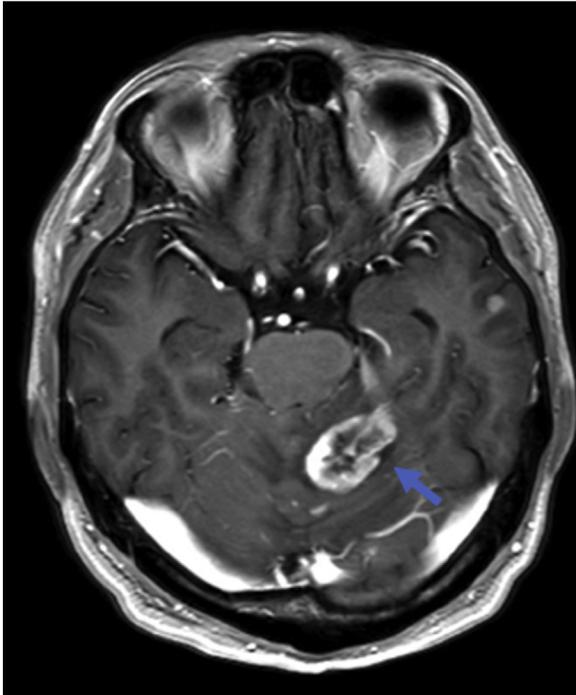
T1-weighted brain magnetic resonance imaging with Gd-DTPA as the contrast. Nodules are visible in the left cerebellum (blue arrow), that salivary cancer cells may have induced the destruction of the blood-brain barrier in our patient in a similar way.
